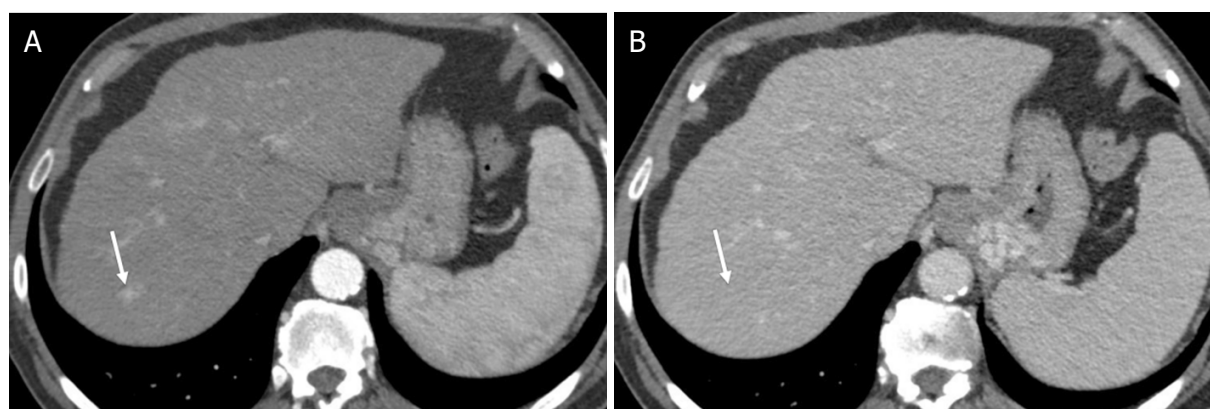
LR-3 (Intermediate probability hepatocellular carcinoma). Axial computed tomography in a 68-year-old man with hepatitis C cirrhosis. Arterial phase (A); and portal venous phase (B) demonstrate a 12-mm observation with nonrim arterial phase hyperenhancement [arrow (A)] and no washout appearance or enhancing capsule appearance [arrow (B)]
